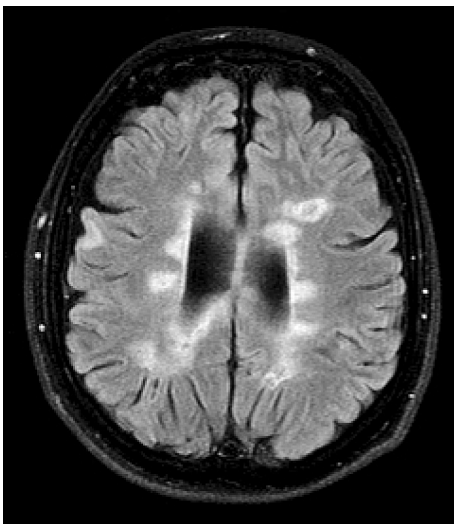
A T-1 weighted Magnetic Resonance Imaging scan of a brain with lesions indicative of relapsing-remitting multiple sclerosis. Bright spots on the scan indicate lesions, or areas affected by inflammation and demyelination.
